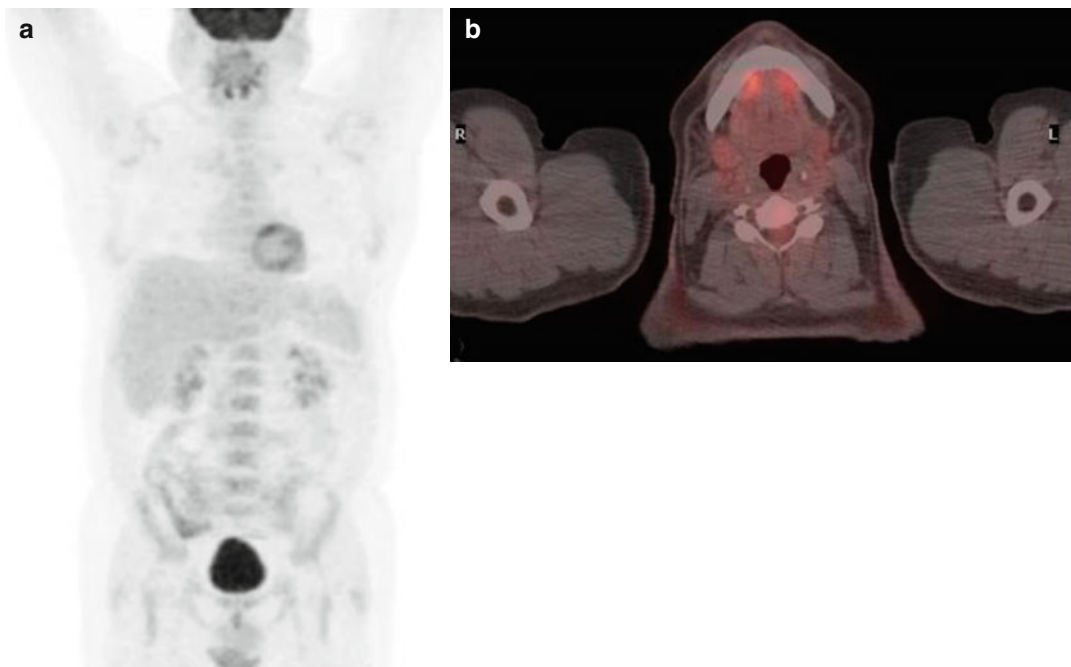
(a, b) MIP-PET and fused PET/CT examination – end of treatment: Negative for abnormal hypermetabolic lesions
